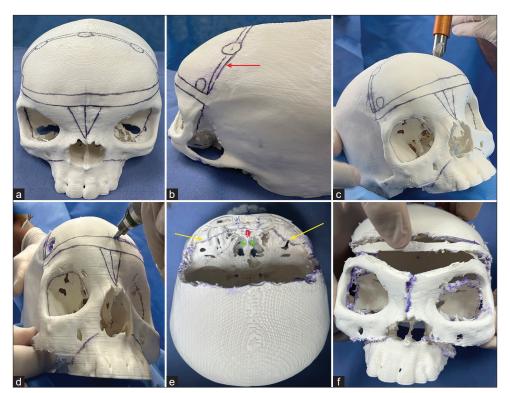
(a-f) The box osteotomy technique was performed on a 3D printer model – polylactic acid. A high-quality computed tomography scan of patient 1 was used as a model. (a) The 3D skull was painted with a dermatological surgical pencil. The frontal craniotomy and a frontal bandeau of 1 cm were maintained between the frontal bone flap and the orbital osteotomies. A V-shaped osteotomy was performed in the midline. The shape and symmetry vary depending on the desired orbital translocation. (b) Craniotomy burr holes were made in the pterional and upper frontal regions. The red arrow represents the trajectory of the craniotomy. (c) Using a special drill, the neurosurgeon drilled holes in the skull to expose the dura. It is important to protect the superior sagittal sinus in the midline. (d) The craniotome connected each burr hole. (e) The frontal bone flap and bandeau were removed, providing access to the orbital roof, greater wing of sphenoids laterally, and medially cribriform plates. Gentle brain retraction was necessary to avoid injury to the crista galli (red color) and cribriform plate (green asterisk) and preserve olfactory function. Yellow arrows demonstrate orbital roofs and midline osteotomies. (f) Final appearance after the box osteotomy technique, showing that both orbits were adequately translocated.
